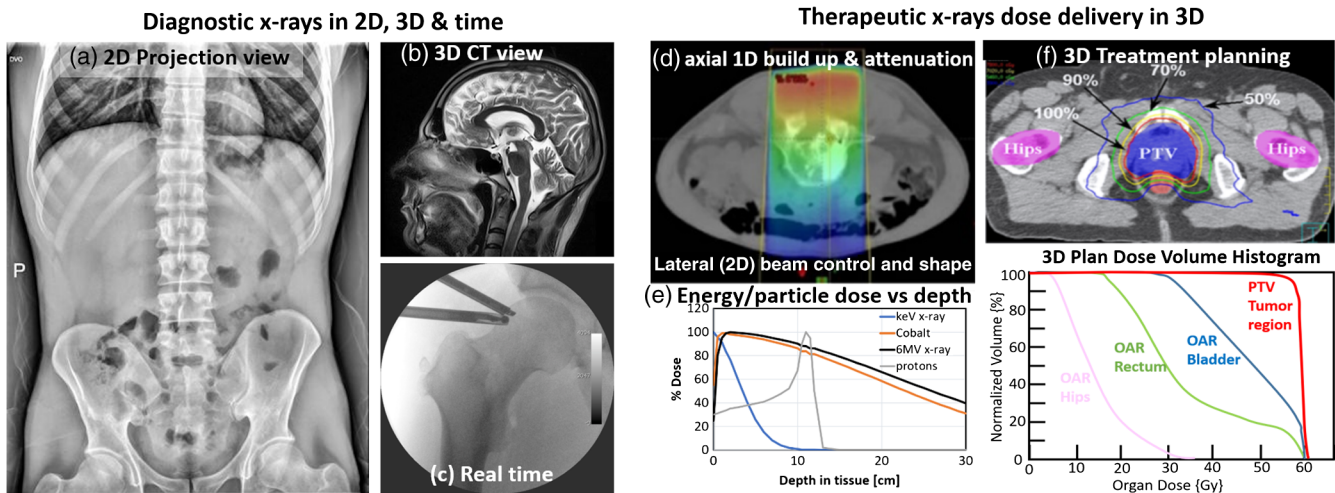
X-ray diagnostic and therapy systems in 2-D and 3-D: diagnostic x-ray imaging systems are widely used in (a) 2-D and (b) 3-D imaging as well as (c) dynamic 2-D (“2.5-D”) during fluoroscopy-guided procedures. In radiotherapy, geometric precision of dose deposition is critical and (d) dose control is obtained laterally by beam collimators and (e) axially by the choice of the beam energy or particle type. Together these axial and lateral controls are used with computational treatment planning tools to optimize a dose plan (f) with a dose volume histogram that maximizes the % area of planning treatment volume while minimizing dose to organs at risk.
